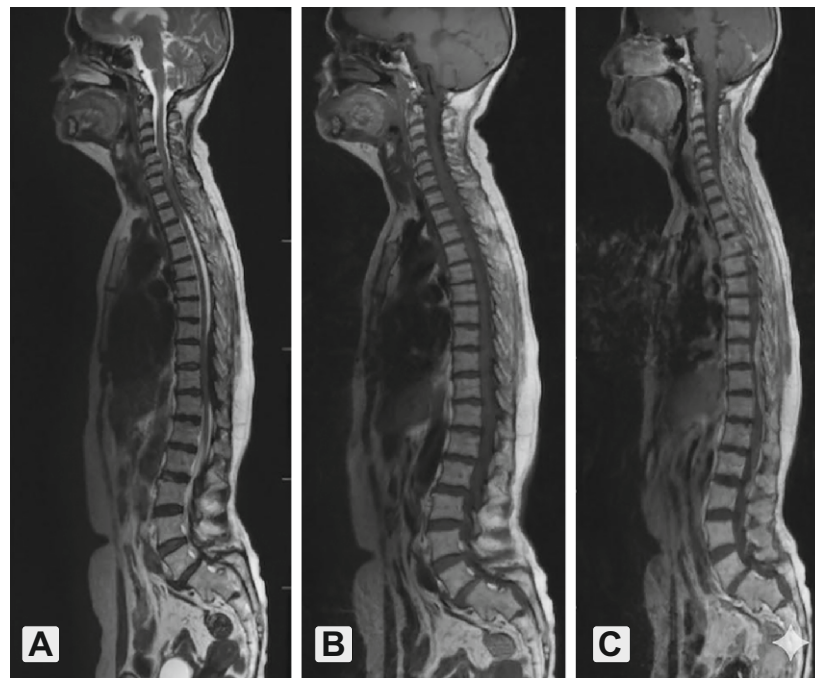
Sagittal magnetic resonance images (MRI) showing two elongated extradural lesions extending from C6 to T2 and T8 to T11, which are iso- to hypointense on T2 (a), isointense on T1 (b), and show homogeneous enhancement on post-contrast images (c).
